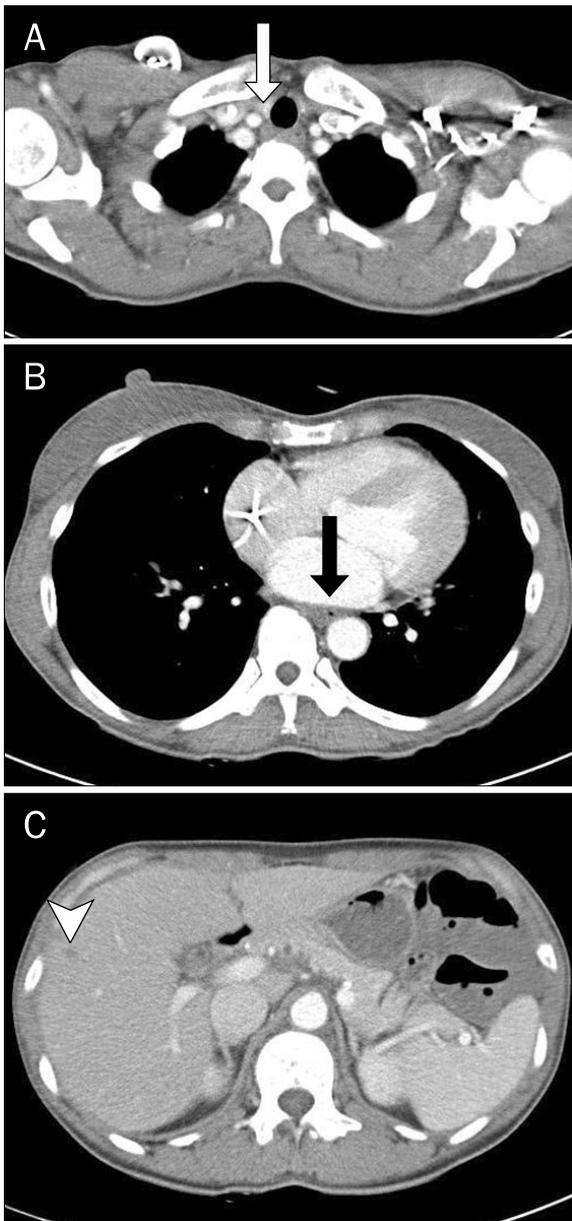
A computed tomography scan showed (A) the primary tumor (white arrow) at the esophagus, (B) a metastatic tumor (black arrow) in the lymph node, and (C) S5 of the liver diminished in size (arrowhead) after chemotherapy and concurrent chemoradiation therapy.
